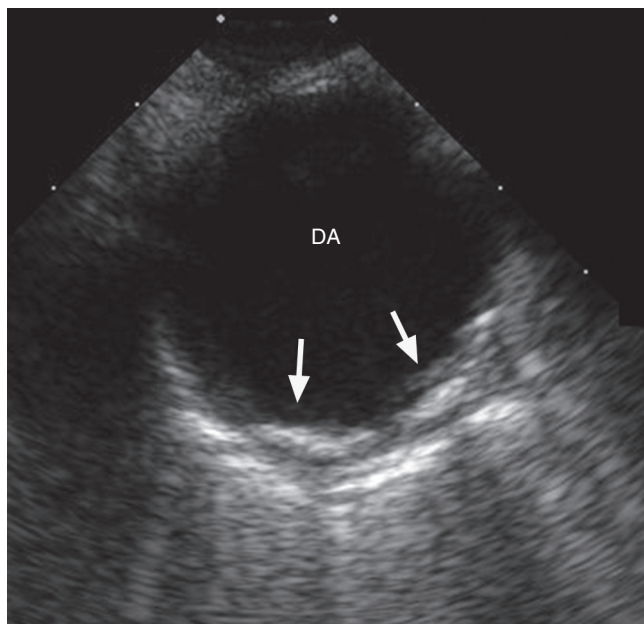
■ Mild atherosclerosis (arrows) of the descending thoracic aorta (DA) imaged by transesophageal echocardiography. Calcification within the atherosclerotic plaque causes acoustic shadowing distally in the far field.
